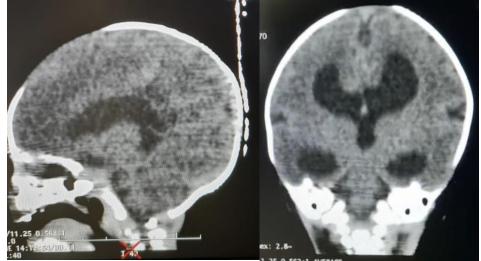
CT brain before external shunt operation, markedly dilated supra tentorial ventricular system (both lateral and third ventricles) with large head feature suggestive non communicating obstructive hydrocephalus. Widening of the lateral ventricles indicated corpus callosum agenesis
